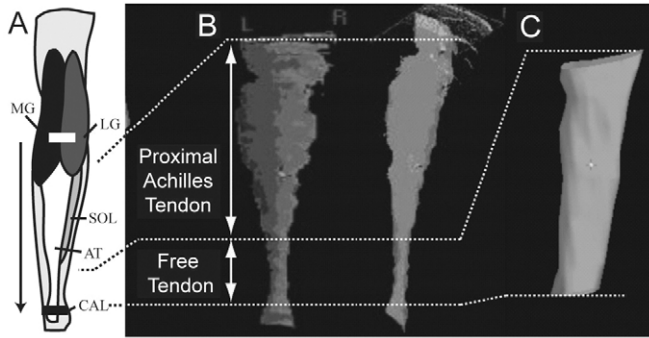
(A) Positioning of the ultrasound transducer and the direction of the sweep (arrow) for the transverse scans. (B) Two views of an example of a reconstruction from a transverse scan showing the proximal Achilles tendon (AT) and the free AT. (C) An example of a reconstruction of the free AT.
